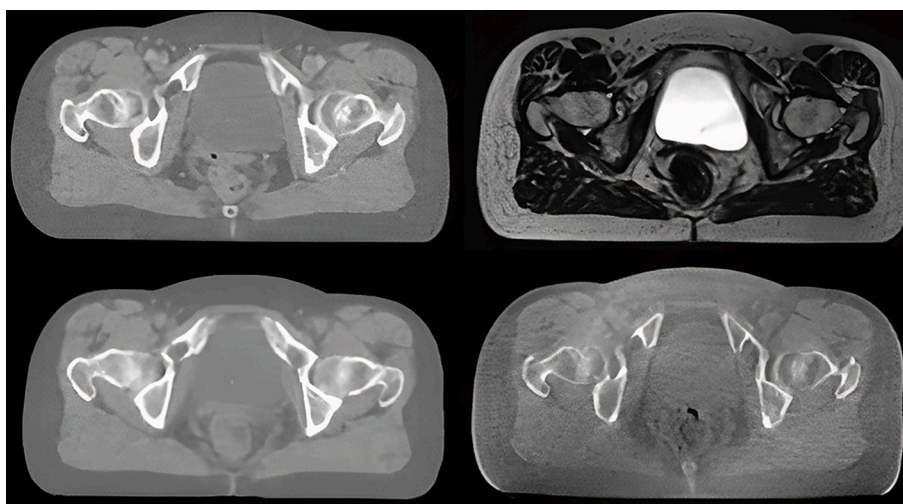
Example of an axial slice of a single anal cancer patient CT (top left), MR (top right), sCT (bottom left) and CBCT (bottom right) scan used for CBCT registrations.
